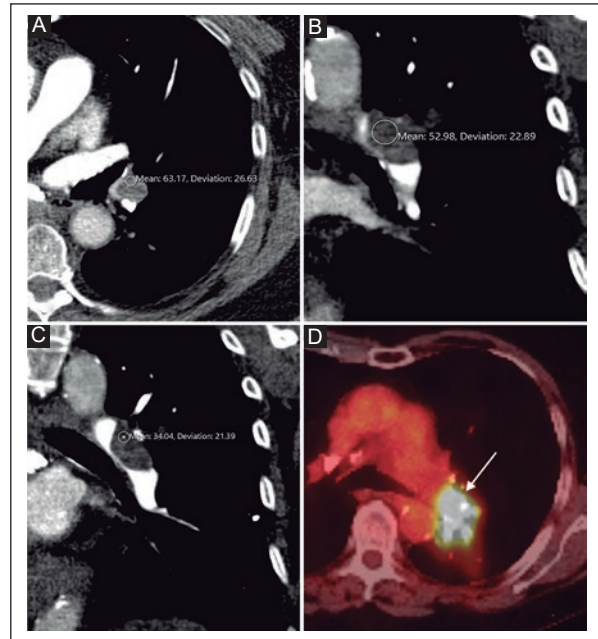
A male patient with pulmonary artery opacification defect. A: CTPA, axial image. B-C: coronal reconstruction. There is a partial opacification defect occupying the pulmonary artery of the left lower lobe, predominantly hypodense, with lobulated contours and enhancement during the administration of contrast medium. D: ¹⁸F-FDG-PET/CT demonstrating marked tracer uptake (arrow). This finding corresponds to a pulmonary sarcoma.
